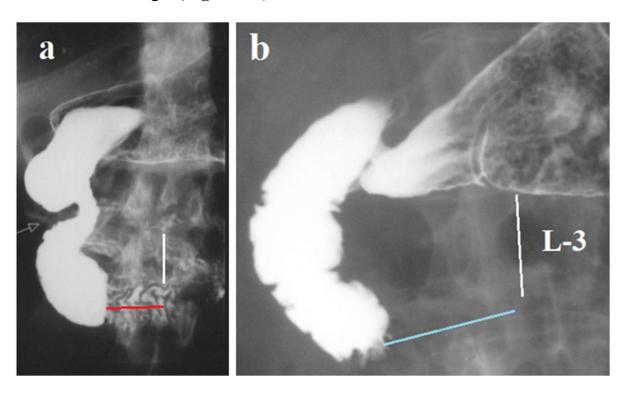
(a) Radiograph from the article by Neri et al. This is the only radiographs, which was supposed to prove the diagnosis of SMAS. Despite hypotonic duodenography the stomach and duodenum are not dilated. The constriction, about 2.5 cm long, which starts to the right of the vertebra, is caused by the contraction of the Ochsner sphincter. The white arrow shows the Kapanji sphincter. Obviously, this radiograph does not differ from the radiograph of our patient (b), who, unlike the patient Neri et al, did not undergo surgery.
